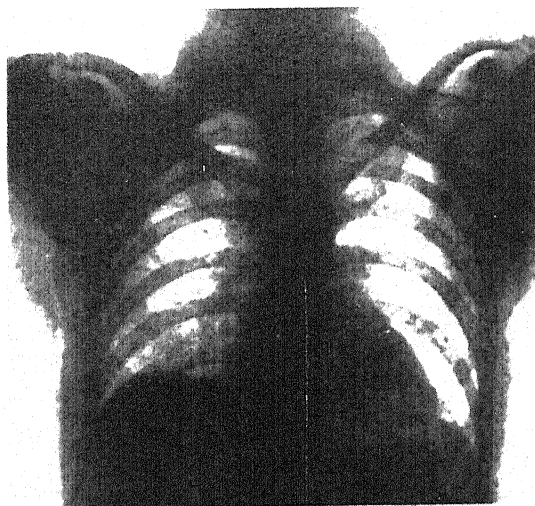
X-ray of thorax in normal expiration.
